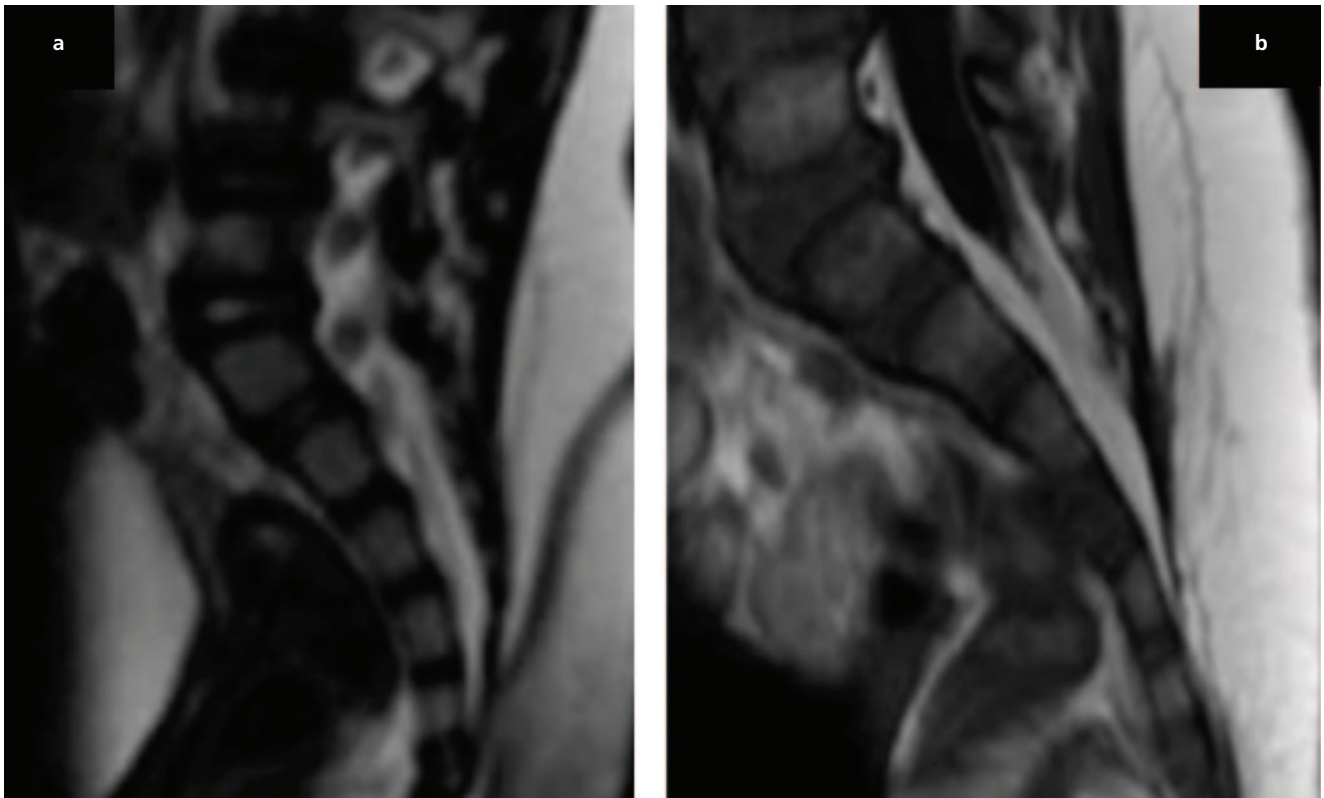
Type 3 coccyx (a) and Type 4 (b) coccyx are shown on sagittal MRI section.
